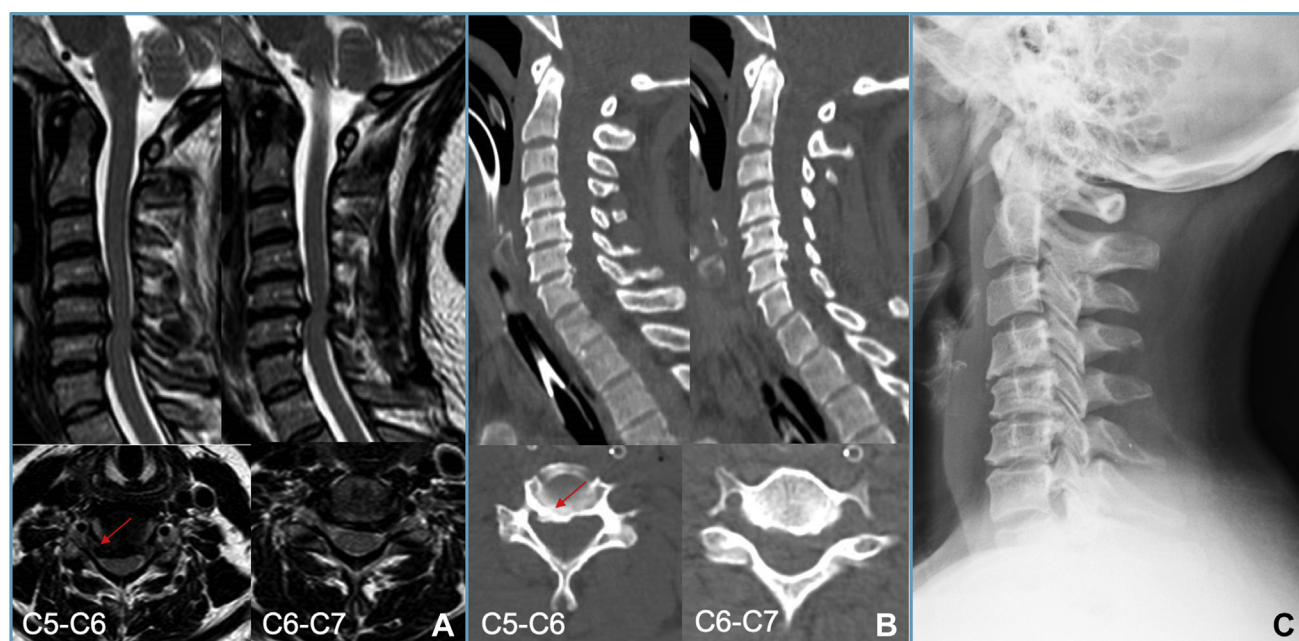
Preoperative (A) sagittal T2-weighted sequences of cervical magnetic resonance and (B) multiplanar reconstructed computed tomography scans depicting spinal cord and nerve root compression at
